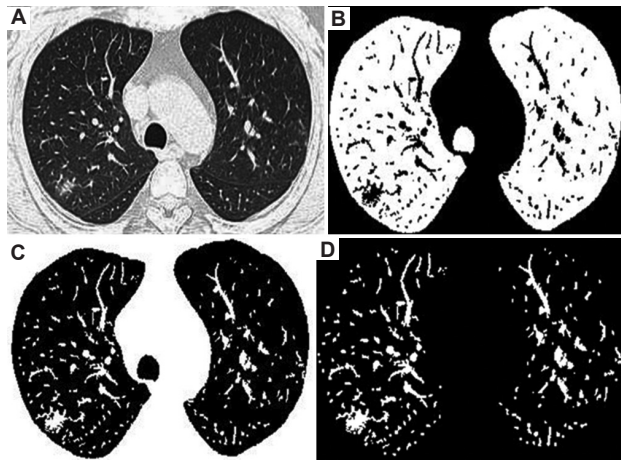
Experimental images obtained for COVID-19 CT slices. (A) COVID-19 input CT slice. (B) Segmented image. (C) Extracted ROI. (D) COVID-19 nodules. These images were generated using Python. Abbreviations: CT: Computed tomography; ROI: Region of interest.
